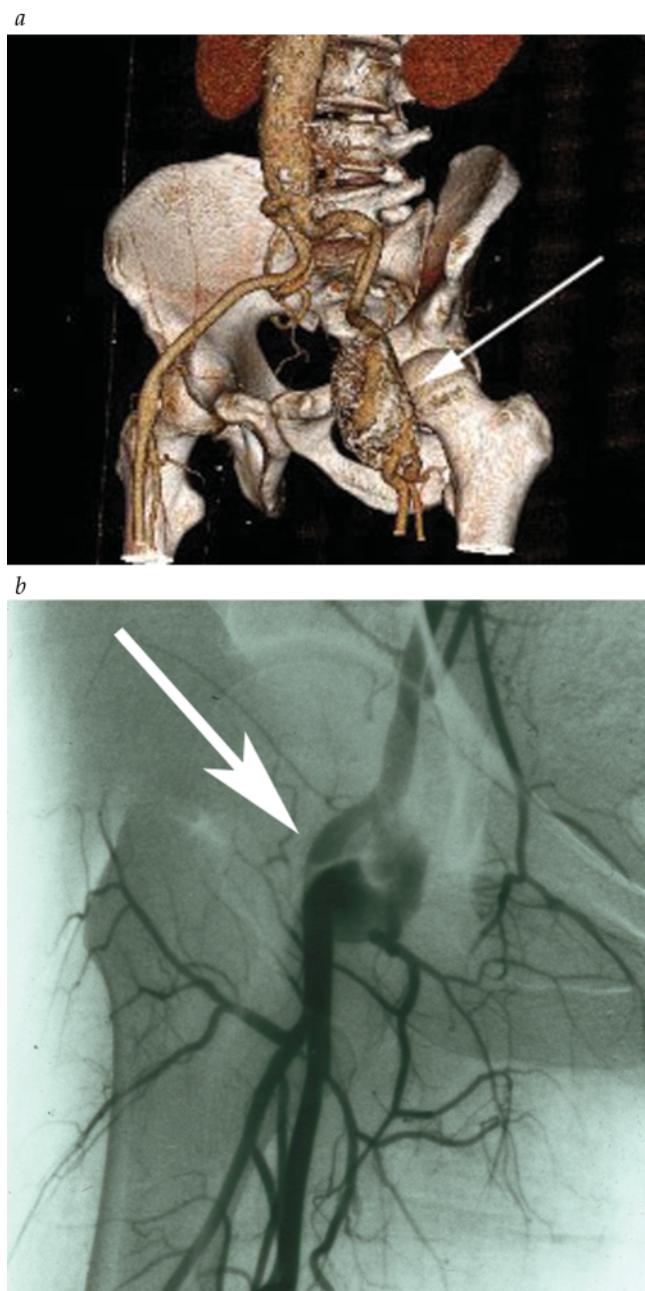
(a) Three-dimensional reconstruction of a computed tomographic scan of a large left common femoral artery aneurysm (arrow). (b) Anteroposterior arteriogram demonstrates a localized common femoral artery aneurysm (arrow).
